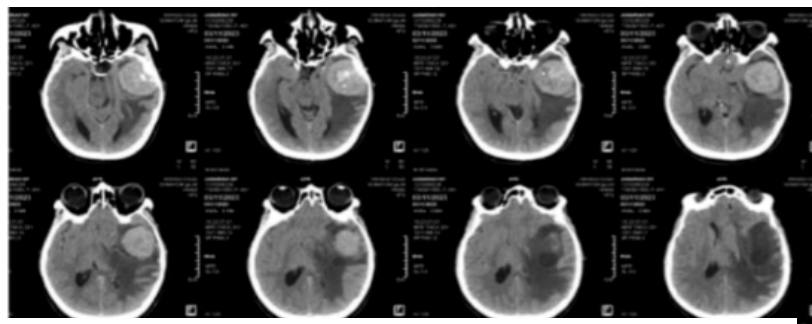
CT brain contrast, November 2023
